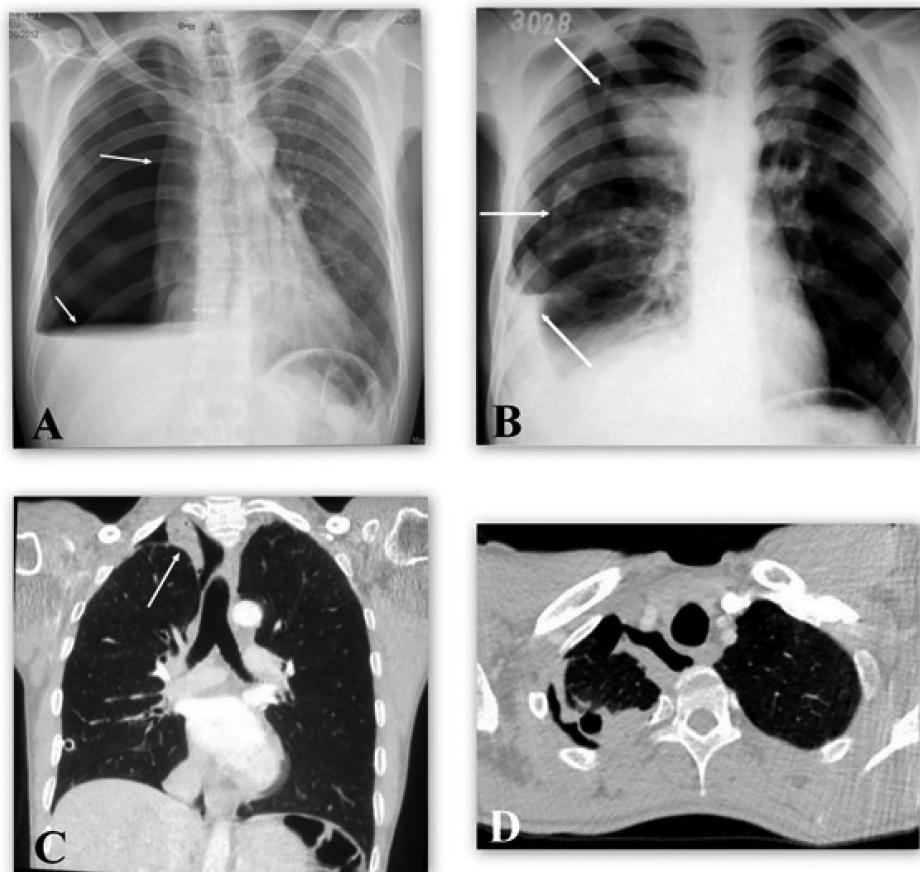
The chest X-ray and CT images of the patients
